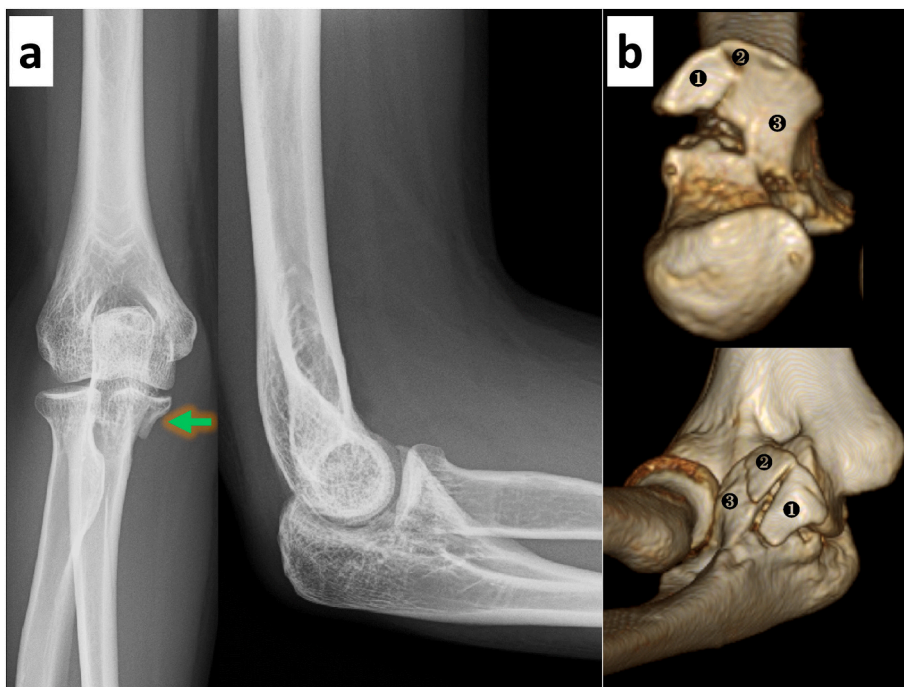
a: Two plain X-ray views at the time of injury (the green arrow indicates the fracture site).
